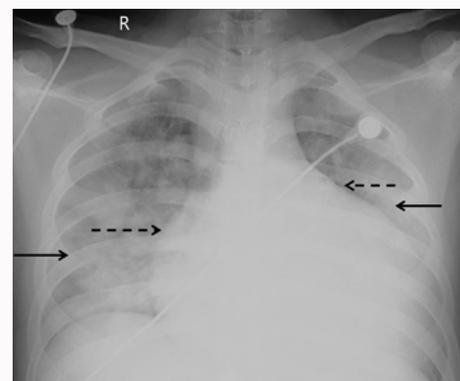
AP chest radiograph of 23-year-old male with dilated cardiomyopathy showing diffuse consolidation bilateral lung fields (black arrows). Note the gross cardiomegaly (dashed arrows).
